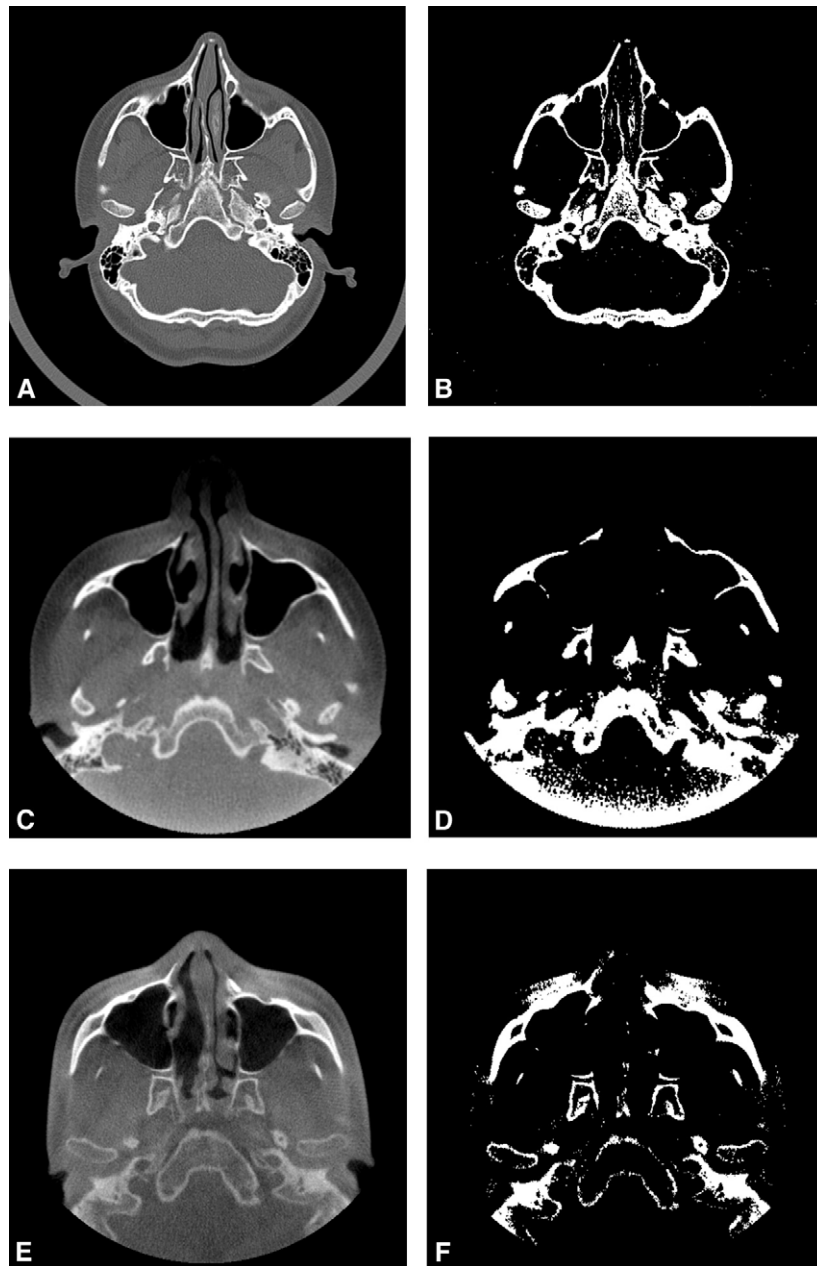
With MS CT imaging: A, image values are related to radio density in a consistent way. B, When image values higher than specific threshold are selected, bone is visualized. Currently, this is not the case for CBCT. With i-CAT (C and D) and Hitachi (E and F) CBCT, there is a variation in image values.
